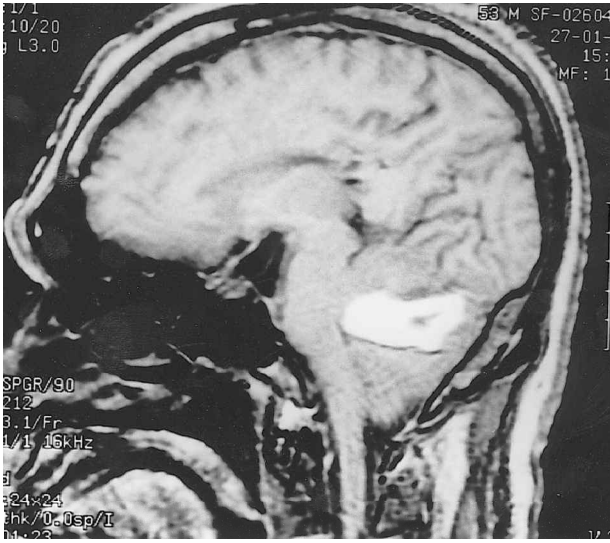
MRI scan showing haematoma in superior cerebellar vermis.
